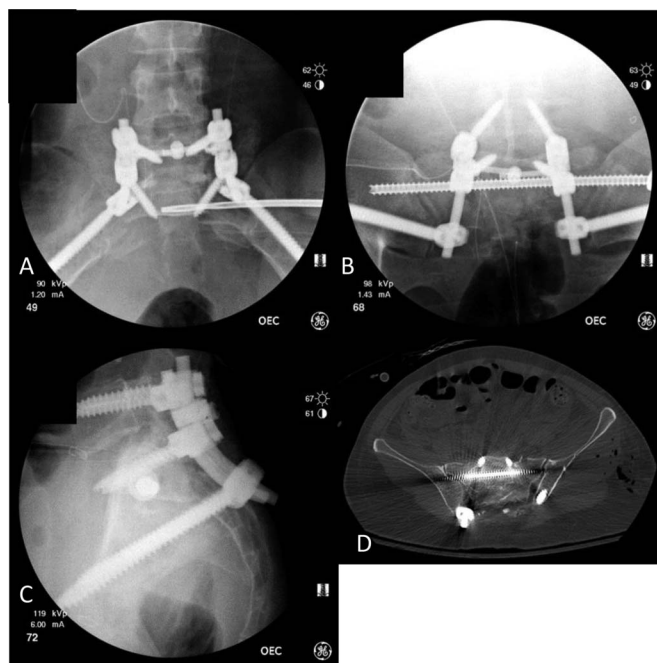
A, Inlet fluoroscopic image. B, Outlet fluoroscopic image. C, Lateral fluoroscopic image. D, Postoperative CT.
